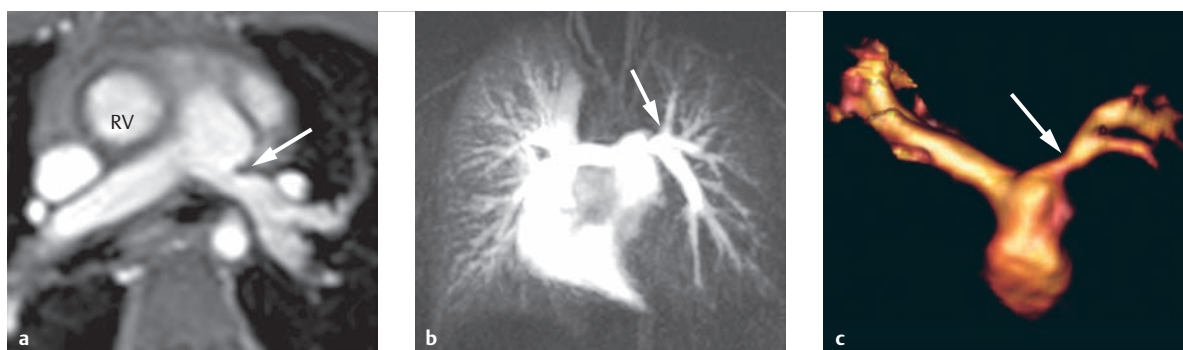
Origin stenosis of the left pulmonary artery in a case of Williams-Beuren syndrome. Six-year-old male patient. The stenosis can be clearly visualized by means of MRI (a–c). Dynamic MRA (b) also depicts the pronounced pulmonary hypoperfusion on the left side due to the relevant stenosis of the left pulmonary artery (a–c, arrows).
